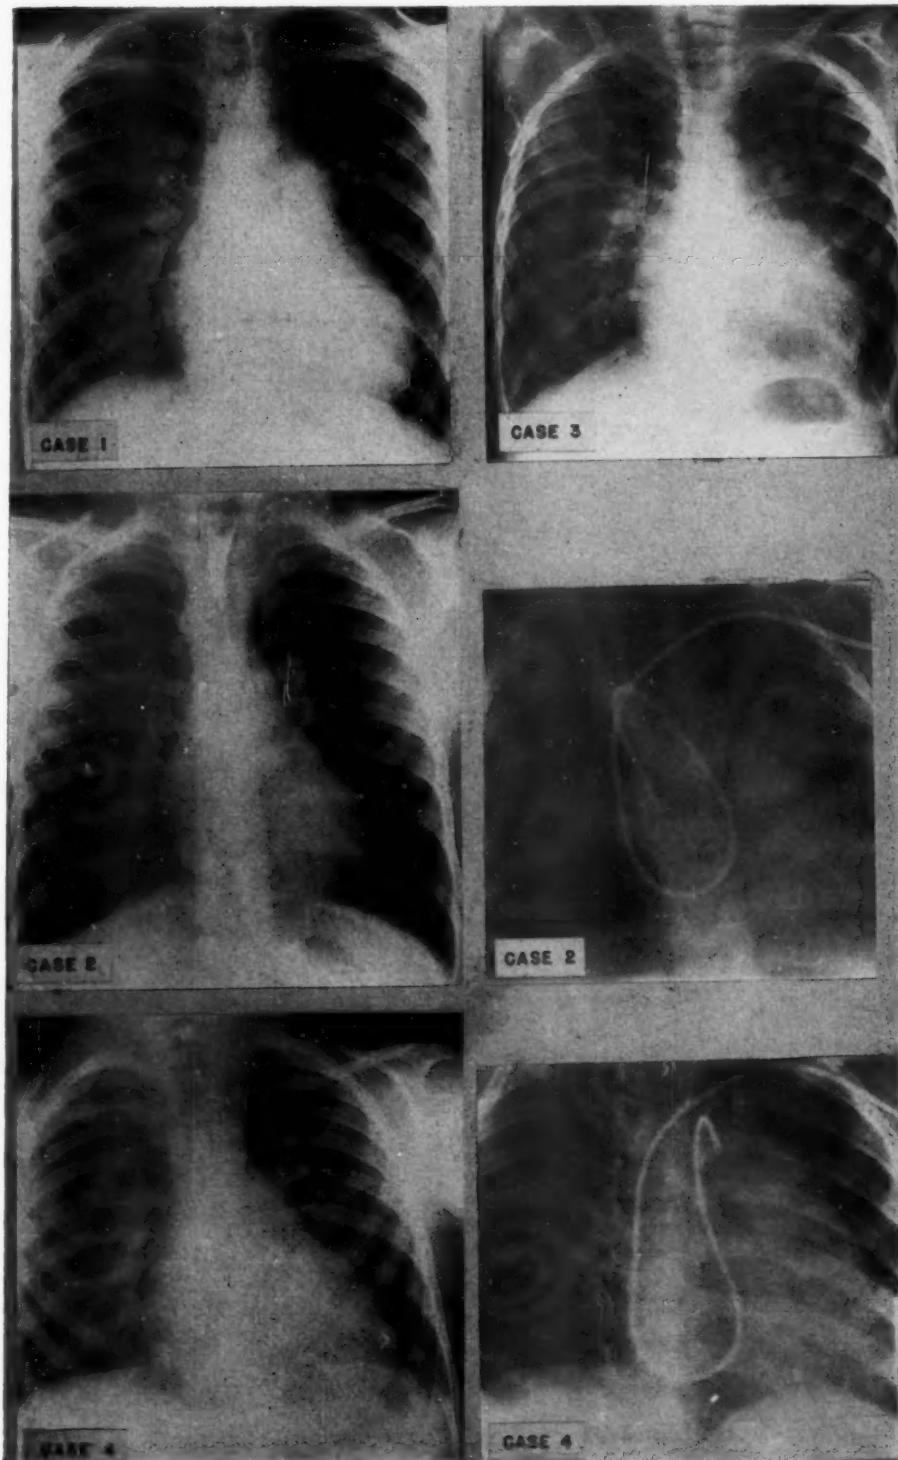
Chest x-rays in four cases of pulmonic stenosis with interventricular septal defect. Film taken at cardiac catheterization in Case 2 shows catheter passing through ventricular septal defect into right-sided aortic arch. Film taken at catheterization in Case 4 shows catheter passing through ventricular septal defect into aorta.
